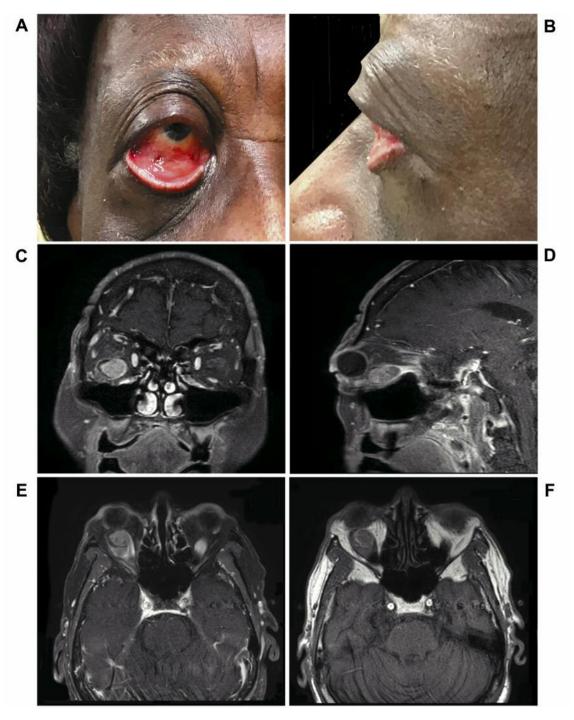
Physical exam and Orbital MRI. Photograph of patient with right eye proptosis in frontal (A) and side (B) views. T1-weighted imaging with coronal view (C), sagittal view (D), axial view after contrast with fat suppression (E), and axial without contrast (F) showing heterogenous hyperintense lesion in the right inferior rectus muscle.
